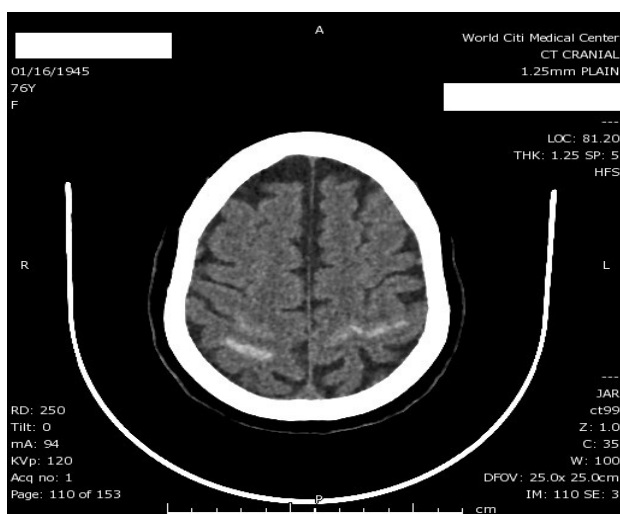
Plain cranial CT scan upon initial consult showing bilateral lobar haemorrhage.
